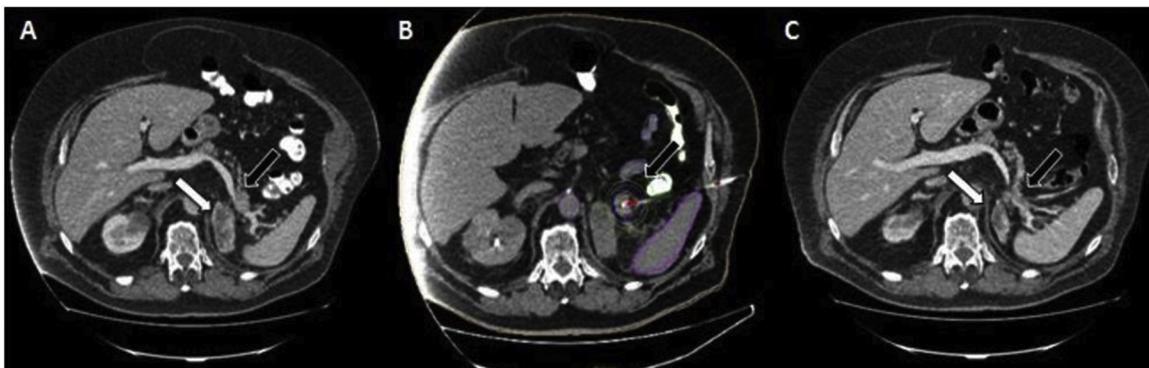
(A): Pre-interventional contrast-enhanced CT slice showing a metastasis of NCC (black arrow) in the pancreatic tail. White arrow shows a metastasis of NCC of the left adrenal gland, previously treated with high dose rate brachytherapy (HDRBT). (B): Planning CT with indicated CTV (red line), catheter (marked in red) and isodose lines. (C): Follow up after 18 months: local control of treated lesion in the pancreatic tail (black arrow). Size reduction of the previously treated lesion in the left adrenal gland (white arrow).
